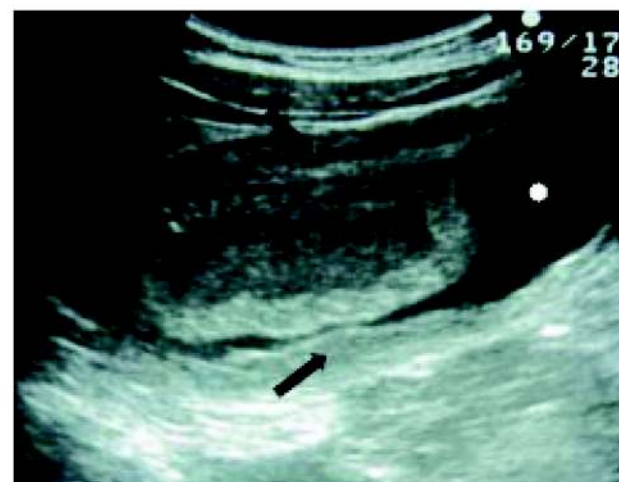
Ultrasound abdomen showing oedematous outer bowel loop (arrows) with fluid between two bowel loops (asterisk)
